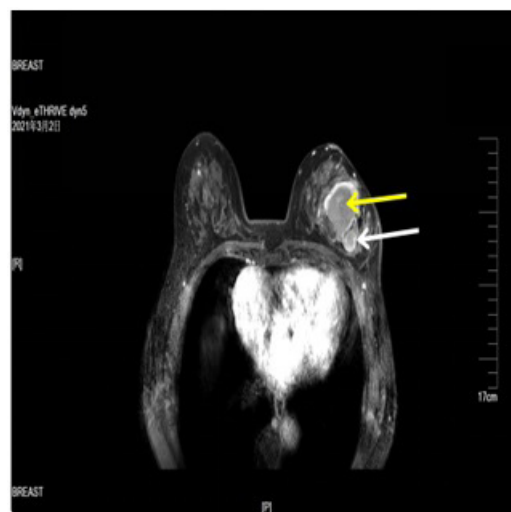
The enhanced MRI showed a cystic lesion with unclear boundary in the left breast upper outer quadrant, the size was 5.4×5.0 cm (yellow arrow) and inside with a solid space-occupying (white arrow). Bilateral breast fibroadenomas were reported.
